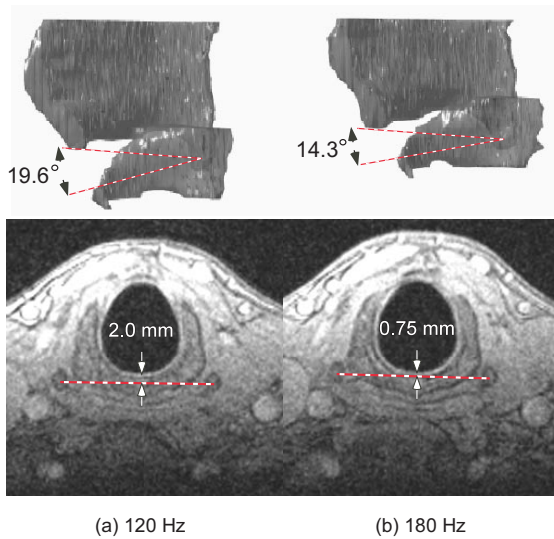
Rotation (top) and translation (bottom) of the joint observed by MRI. The top figure shows the right half of the 3D image of the cartilages. Note that the cricoid cartilage rotates and translates as seen in the location of its arch. The bottom figure shows the transverse images of the larynx sectioned at the cricothyroid joint. The inferior horns of the thyroid cartilage indicated by the line translate forward in high F0.
